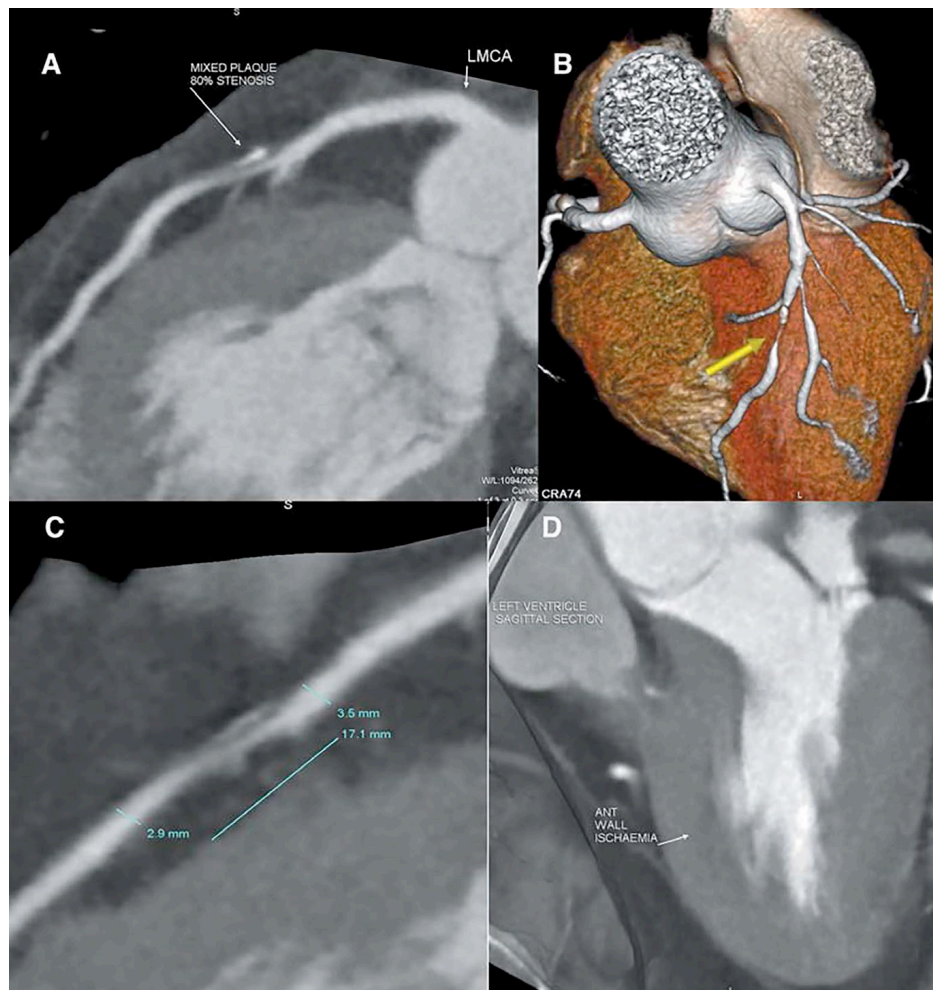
Panel A shows a curved reconstruction with a mixed plaque in the mid LAD. The 3D image gives the relation of the stenotic segment to side branches as well as the curvature of the artery in panel B. The lesion length and vessel diameter can be measured in Panel C. Panel D shows the myocardium in the 2 chamber long axis view revealing a dark area in the sub-endocardium of the anterior wall representing a perfusion defect at rest. Patient was scanned on a uCT 780 (United Imaging Healthcare, Shanghai, China) 160 slice cardiac CT scanner.
